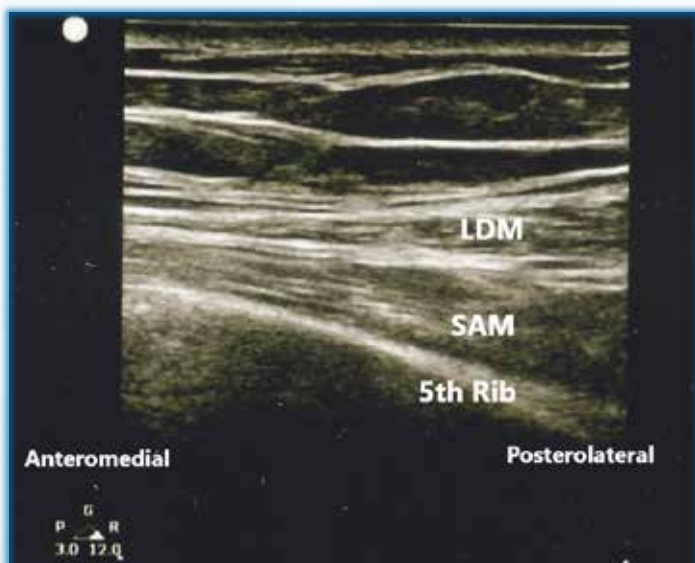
Ultrasound view of the SAP block. LDM = latissimus dorsi muscle, SAM = serratus anterior muscle
